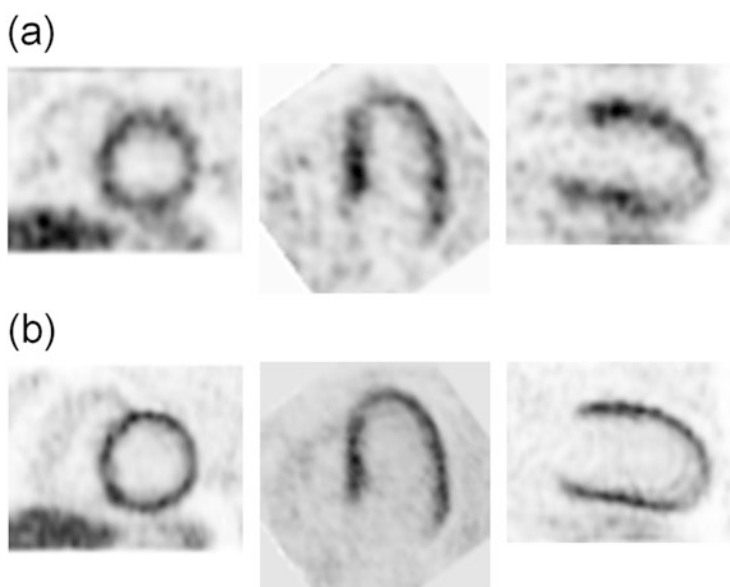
(a) Sample images from one of the six respiratory-gated frames and from selected sample (*Left*) short-axis, (*Middle*) horizontal long-axis, and (*Right*) vertical long-axis slice images obtained using a 3D OS-EM image reconstruction without any motion compensation from a  $^{18}\text{F}$ -FDG cardiac PET study. (b) The sum of all six respiratory-gated frames from (a) showing the effect of RM blur. (c) Corresponding sample images as in (b) obtained using the 4D OS-EM image reconstruction with RM and attenuation compensation showing the reduction of RM motion blur in the reconstructed images
